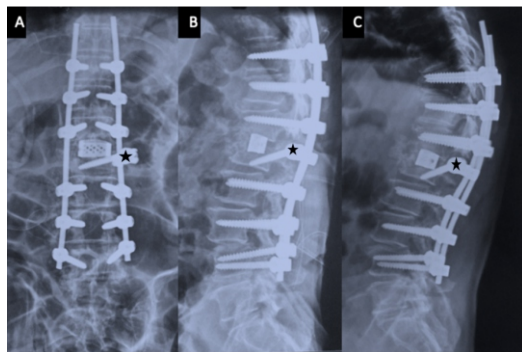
(A, B) Radiographs after 2nd surgery with anterior bonegraft, cage interbody reconstruction, correction of deformity and rod exchange. Opening up of the index surgical region was needed. The new rod was intentionally kept longer at proximal junction (PLRT-presumptive long rod technique). Note the Offset screw (*) with extrapedicular trajectory connected with offset connector. (C) 5 months post-operative follow-up, patient developed osteoporotic fracture in T10, the upper instrumented vertebra.
